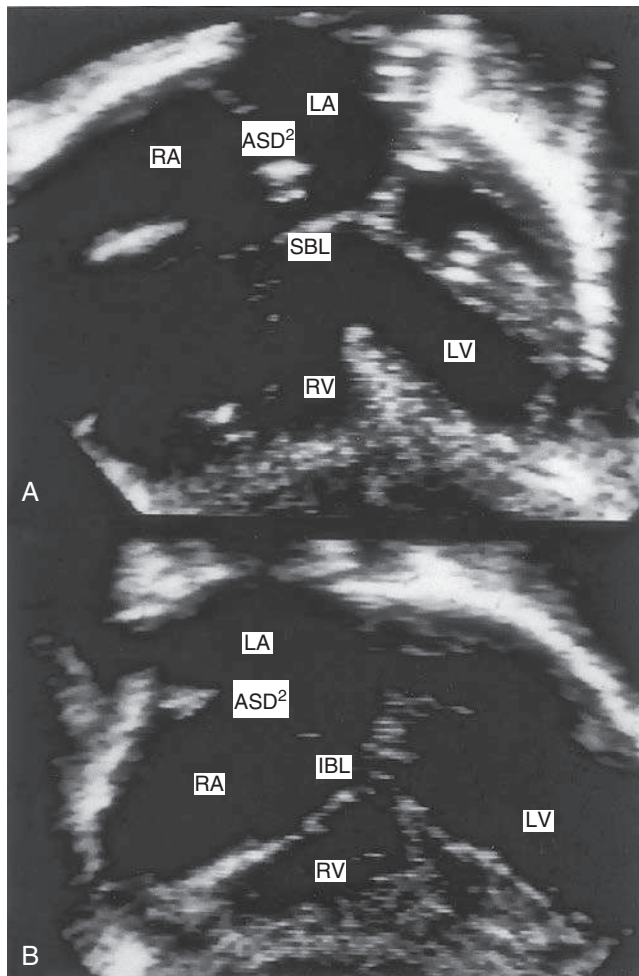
A, Apical four-chamber view showing the superior bridging leaflet, immediately above which is an ostium primum ASD and below which is a large inlet ventricular septal defect (VSD). The patient also has an ostium secundum ASD (ASD2). B, Subcostal four-chamber view showing IBL with a small VSD beneath. Note that both AV valves are at the same septal insertion plane (as opposed to the normal mitral and tricuspid valve, where the tricuspid valve is relatively apically displaced). Also note marked right ventricular hypertrophy. ASD, Atrial septal defect; IBL, inferior bridging leaflet; LA, left atrium; RA, right atrium; LV, left ventricle; RV, right ventricle; SBL, superior bridging leaflet.
